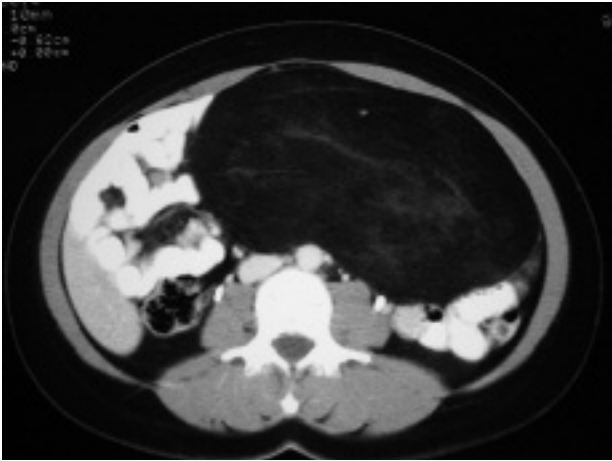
CT scan: abdominal, dishomogeneous, low-density mass with small bowel dislocation but without infiltration.
